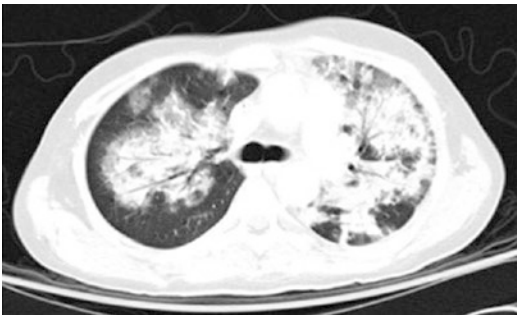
Diffuse Alveolar hemorrhage (DAH) post-HSCT. Chest CT image showing bilateral areas of consolidation in a patient with DAH (From Amy K. Chi, Ayman O. Soubani, Alexander C. White, Kenneth B. Miller, An Update on Pulmonary Complications of Hematopoietic Stem Cell Transplantation, Chest, Volume 144, Issue 6, 2013, 1913–1922, <https://doi.org/10.1378/chest.12-1708>)
